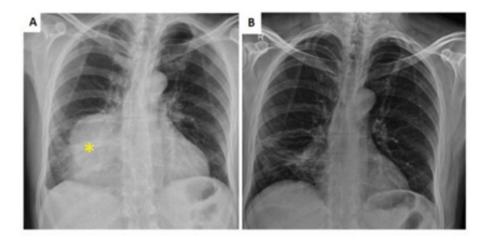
(A) A direct chest radiography revealed a radio-opaque mass in the pericardiac area of the right lung (asterisk). (B) After initiation of chemotherapy, a direct chest radiography demonstrated a response with only minimal residual disease.
